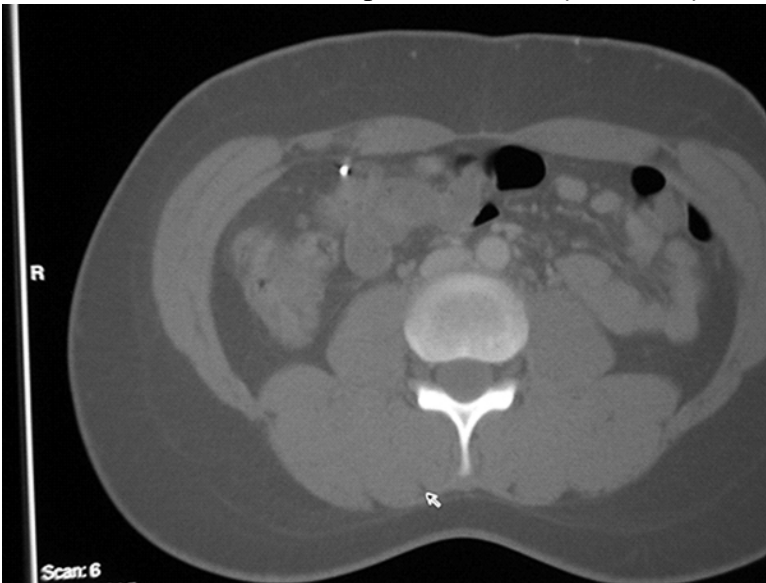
Fragment as seen on CT
